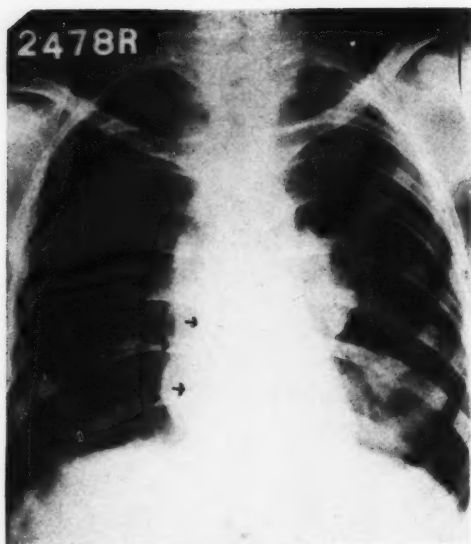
Postero-anterior roentgenogram of the chest of Case 1. Note the large shadow (indicated by the outer arrows) of the abscess superimposed upon the heart and large vessels. The abscess is exaggerated in size because of its distance from the film. The inner arrows on the right indicate the cardiac outline.
